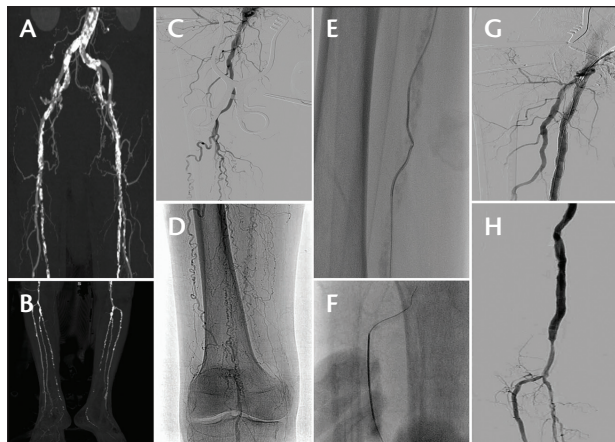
CT angiography demonstrating heavily calcified occlusions of the iliofemoral segment, SFA, and proximal popliteal arteries (A). Two-vessel runoff via the anterior tibial and peroneal arteries can be seen (B). After femoral endarterectomy (C), a 6-F sheath was placed through the suture line into the SFA. Antegrade wire passage to the reconstituted below-knee popliteal artery was attempted but unsuccessful (D). The wire was fed into the antegrade catheter in the mid-SFA (E) following retrograde proximal anterior tibial artery puncture (F). After nitinol stent insertion and postdilatation, the common femoral, SFA, popliteal, anterior tibial, and peroneal arteries were patent with brisk flow (G, H).
